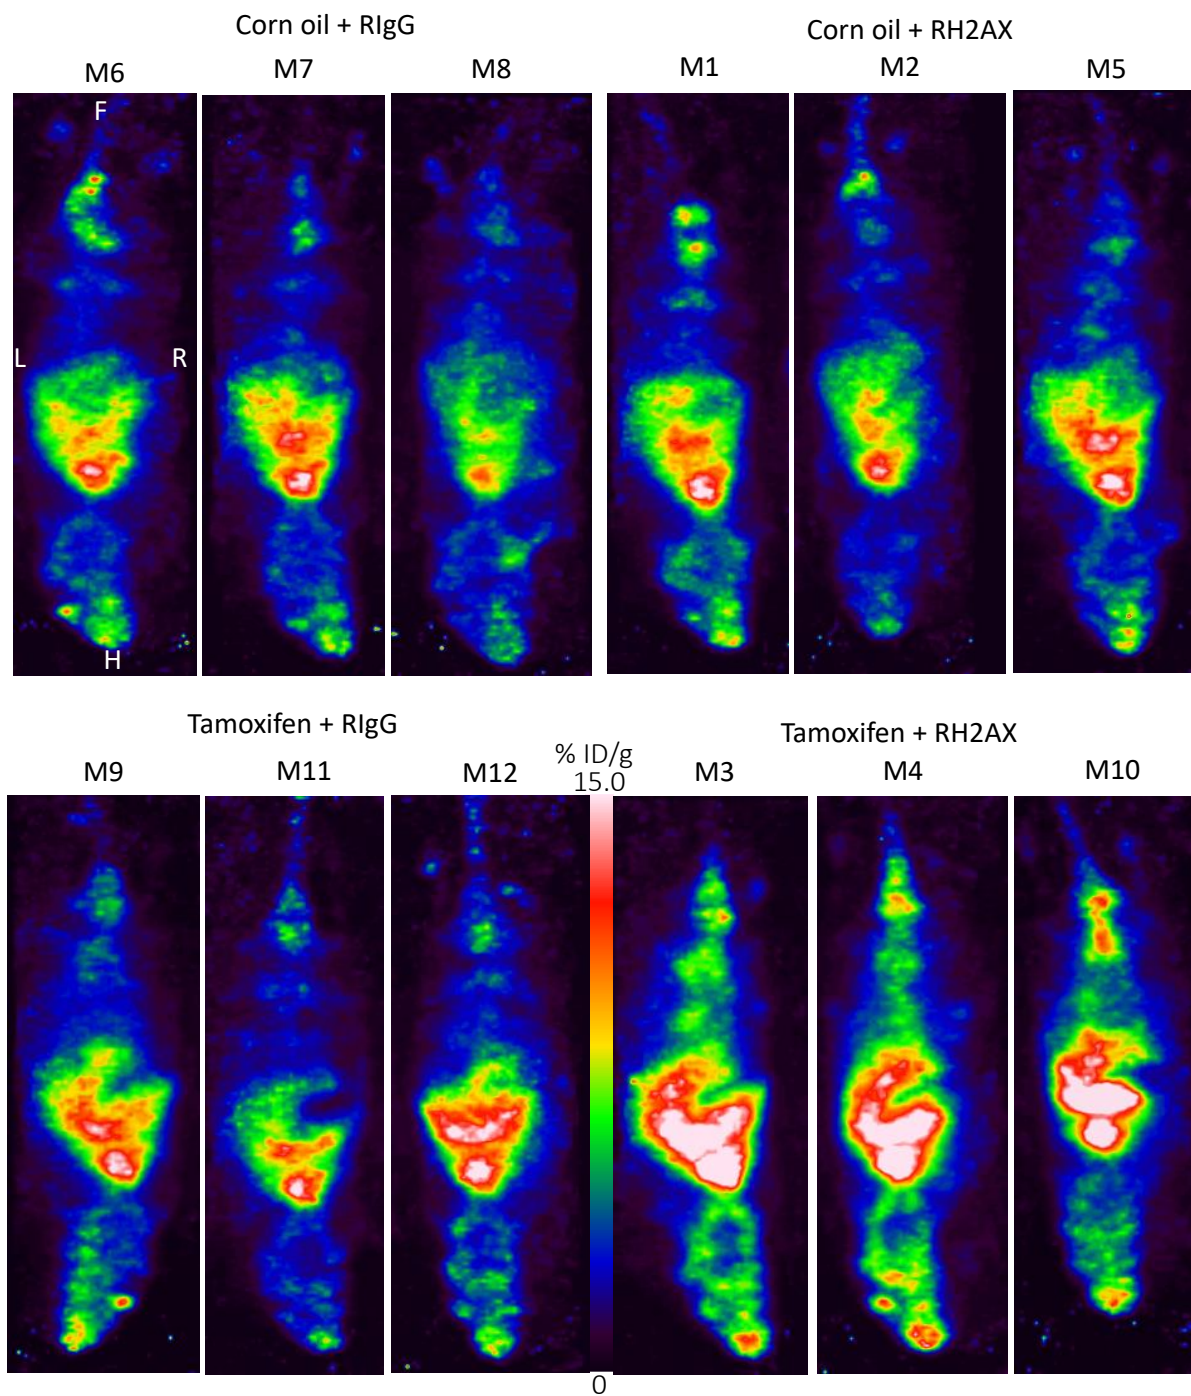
6 Full panel of SPECT images (oral gavage)
